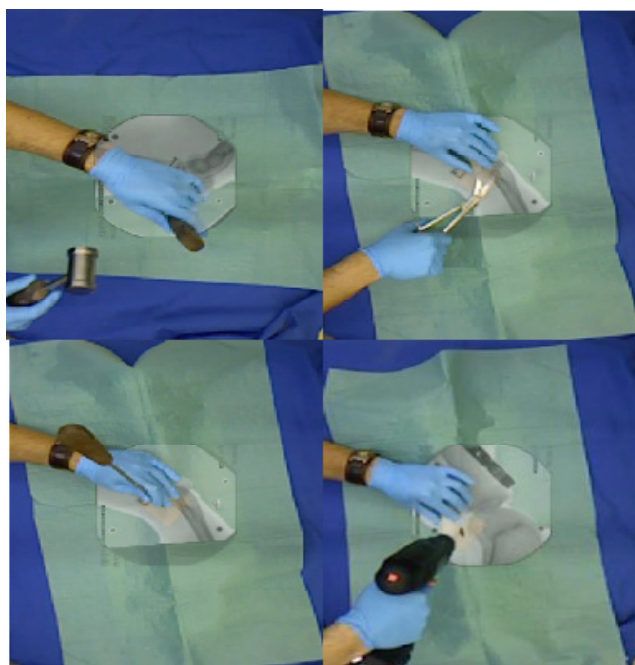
Example visualizations between X-ray and video images demonstrating center punching, drilling and clamping tasks.
